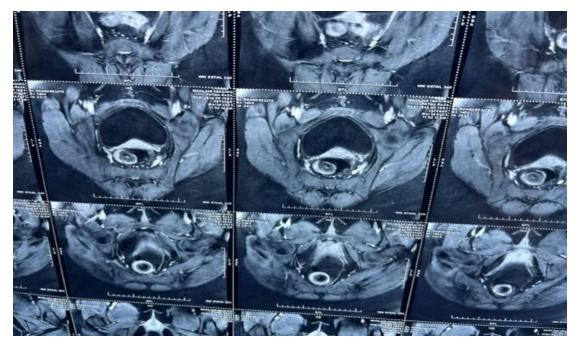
Coronal view of MRI showing intra-luminal tumor arising from left posterolateral wall.
